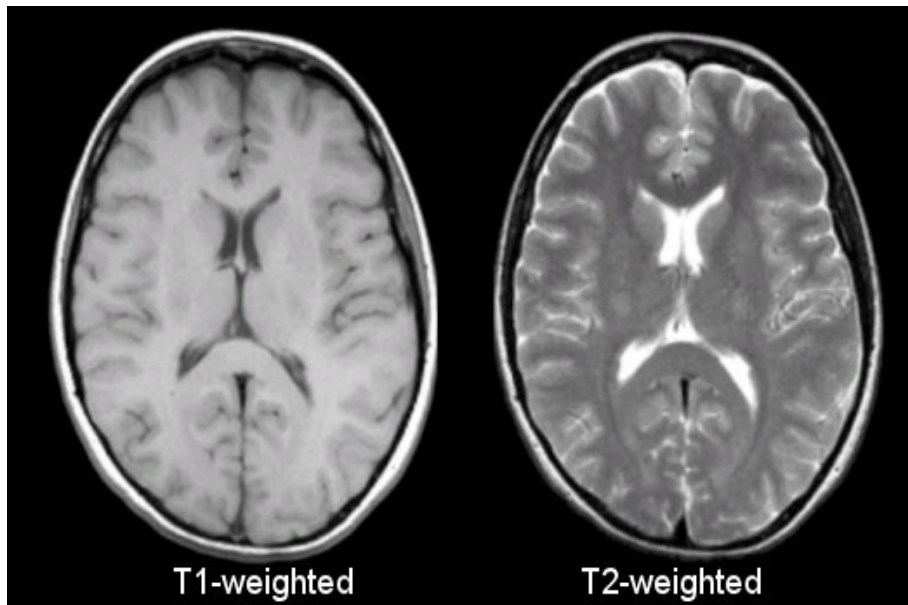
T1-weighted images show fat and white matter in light, while the CSF and the cortex appear dark. In T2-weighted images, the CSF and the fat are light while white matter and the cortex appear dark.
